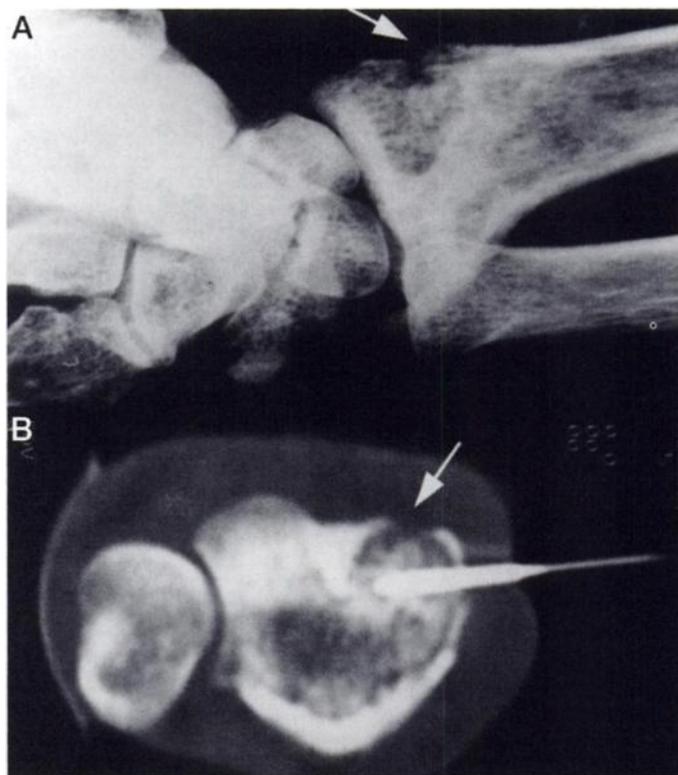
(A) Plain film and (B) CT scan of the wrist reveal an osteolytic lesion with sclerotic margin and periostitis in the distal radius. Cortical breakthrough is noted (arrow). CT-guided biopsy was performed.
